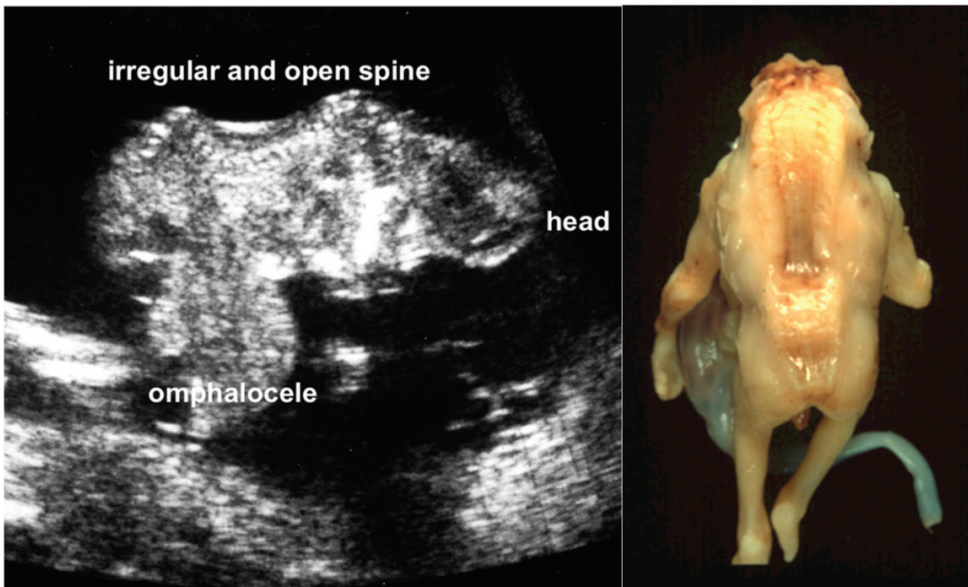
Ultrasound image and postmortem photography of a 14-week fetus with craniorachischisis, 1996. The ultrasound image shows a sagittal section through the body with irregular and open spine, abnormal head pole, and a large body wall defect—omphalocele. Associated anomalies: trisomy 18, omphalocele, and horseshoe kidney.
